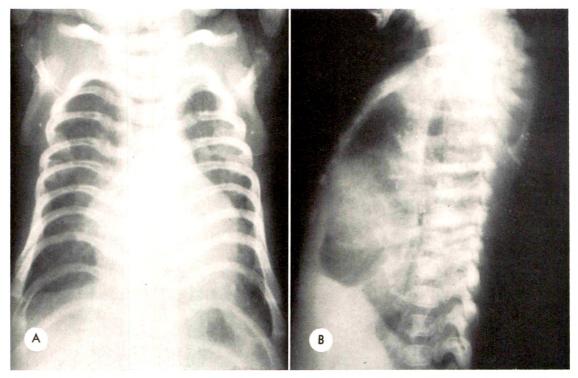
Case I. (A) Posteroanterior and (B) lateral roentgenograms of the chest. Notice the markedly hypoplastic and short ribs which are terminating laterally with their ends barely showing on the posteroanterior roentgenogram. The anterior chest wall is abnormally high with the ribs retaining a horizontal position and the clavicles being abnormally high. The spine appears normal.
